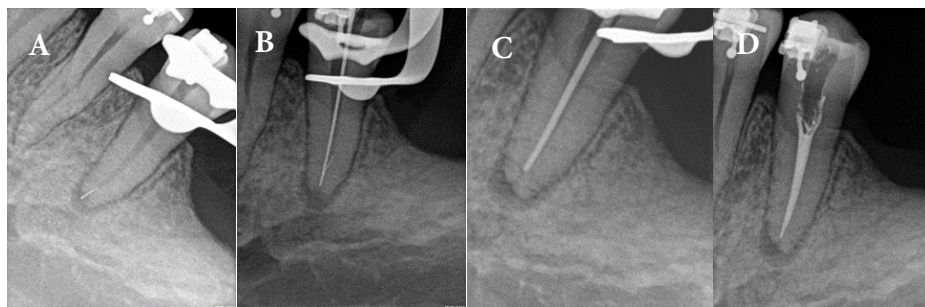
Root canal treatment of the mandibular left second premolar; A) A) Initial radiograph and K-file #10 broke; B) Conductometry (working length determination); C) Conometry (master cone confirmation); D) Obturation
